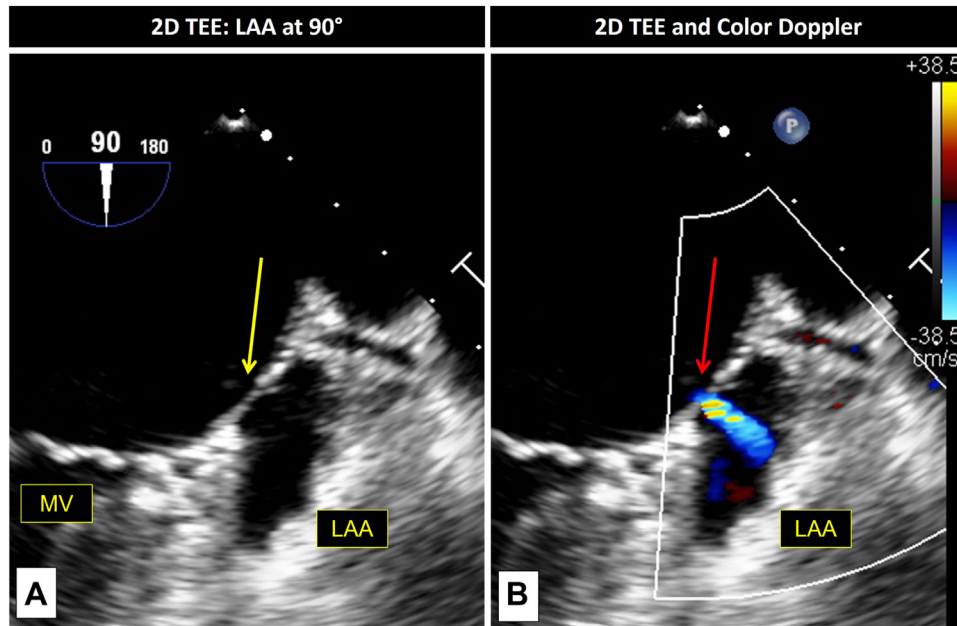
Double-orifice LAA on two-dimensional (2D) TEE. Two-dimensional, zoomed TEE, midesophageal long-axis view of the LAA (90°) without (A) and with (B) color flow Doppler, demonstrating a thin membrane (yellow arrow) across the orifice with flow between the left atrium and the LAA (red arrow). *MV*, Mitral valve.
